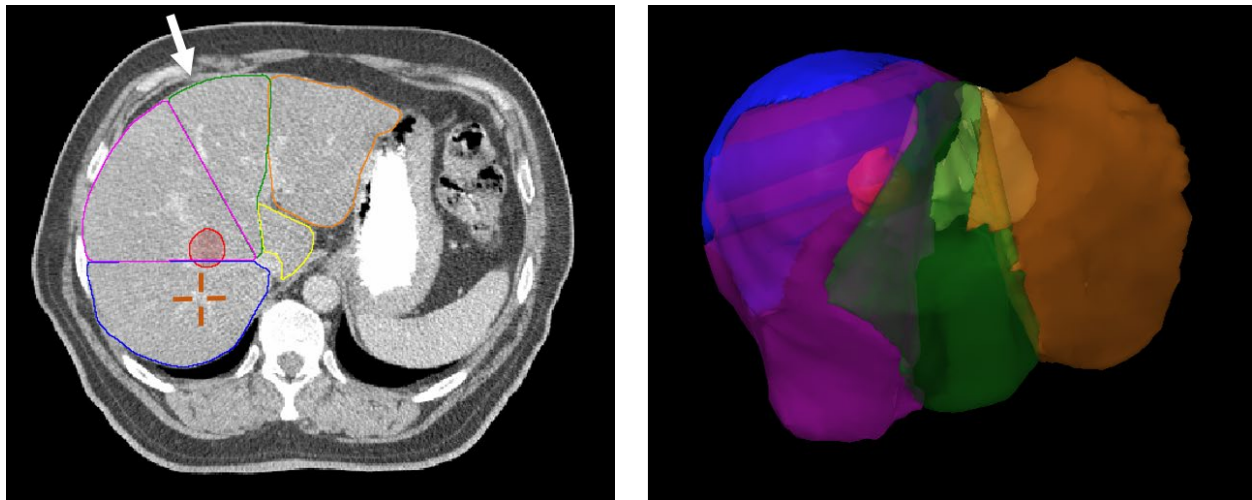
Liver segmentation shown on 2D axial CT slice (left) and 3D volume rendering (right) in the perspective indicated by the white arrow. Identified structures include the left lateral (orange), left medial (green), right anterior (purple), right posterior (blue), and caudate (yellow), GTV (red), and one example vessel bifurcation (orange crosshair).
